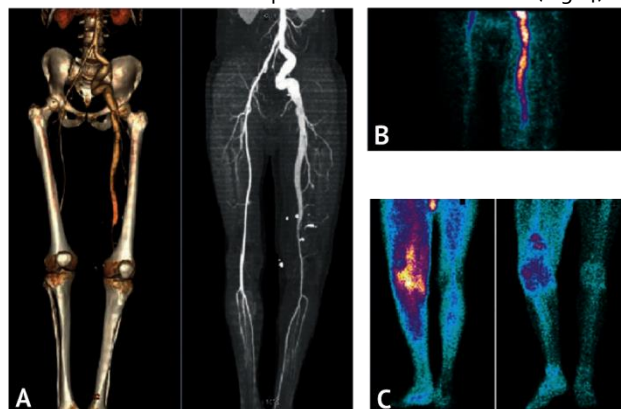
Hybrid examination on day 7 after surgical treatment: A — CT-angiography of lower extremities: VRT and MIP (anterior projection); B — radionuclide angiography (anterior projection): unaltered arterial blood flow, pseudoaneurysm cavity is not detected; C — scintigraphy in soft tissue-phase and bone-phase (posterior projection): increasing of perfusion disorder in the region of knee joint due to recovery of venous outflow from distal region of the lower extremity
